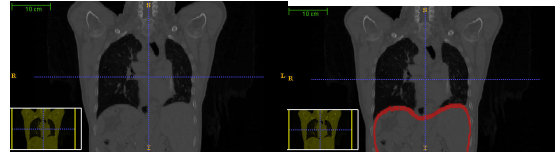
CT coronal slice of the thorax with (a) the original image and (b) the image with the segmented diaphragm (using a red marker).
